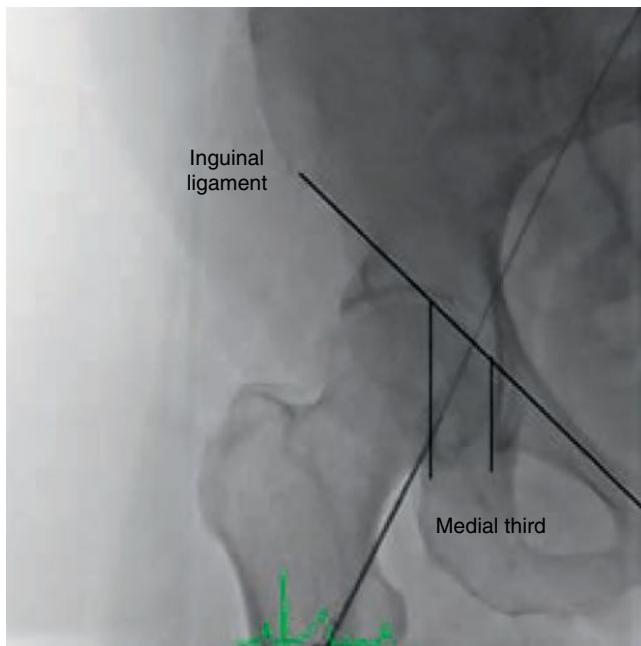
Anatomy of the femoral artery with the inguinal ligament and femoral head delineated. The common femoral artery lies over the medial one-third of the femoral head. A wire is located within the femoral artery in this X-ray image.
